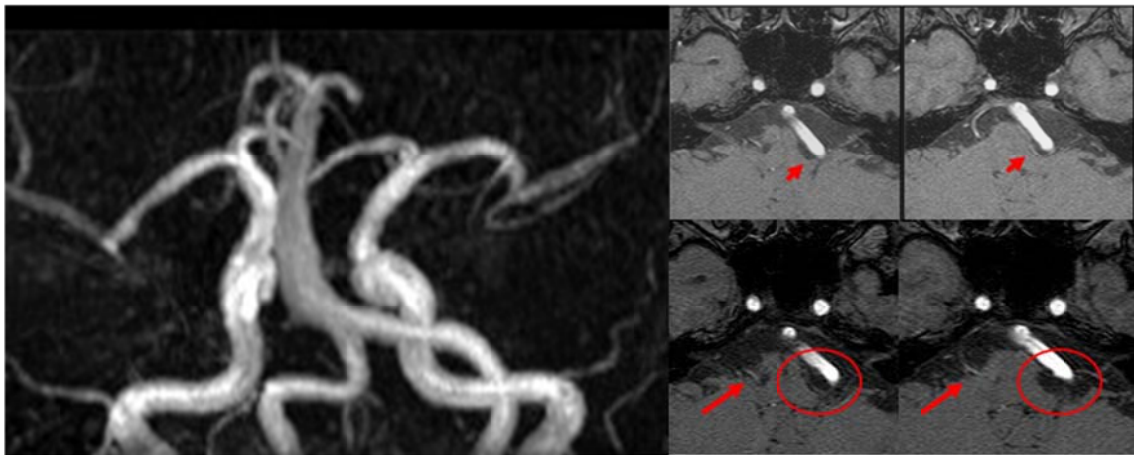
Preoperative and postoperative MRI of a patient with bilateral HFS. The patient was 50s woman with bilateral HFS. Left side facial spasm resulting from VA and PICA occurred one year before first MVD. Preoperative MRI showed that dolichoectatic VA and PICA compressed left facial nerve at the REZ (*short red arrow*). After MVD, left HFS completely resolved but transient facial palsy and hearing impairment occurred. Right side HFS occurred 4 years after left MVD. We obtained postoperative MRI showing that only AICA compressed facial nerve (*long red arrow*) and that complete decompression of left facial nerve was done (*red circle*). After right MVD, right HFS completely disappeared without any complication. In the right HFS, VBD did not affect the offender.
